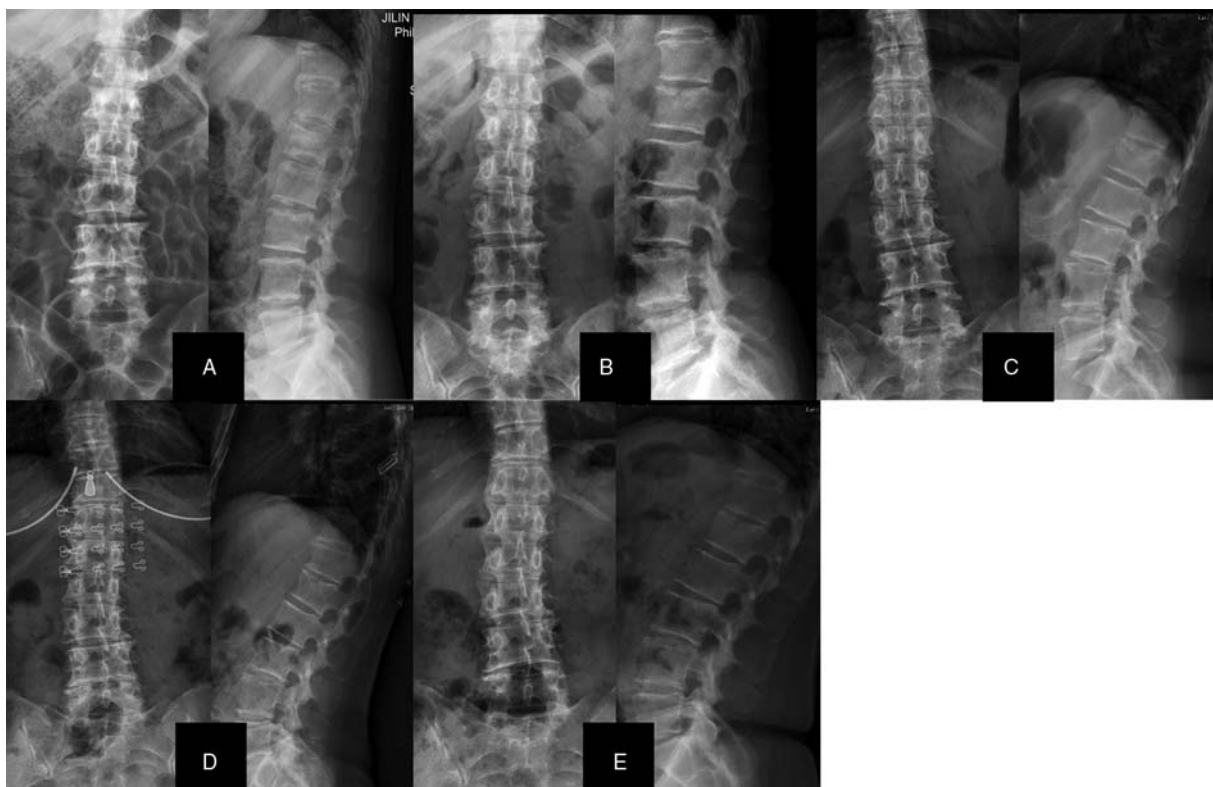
Postoperative x-ray examination of spine. X-ray films of (A) 1 d, (B) 30 d, (C) 60 d, (D) 180 d, and (E) 840 d after operation.
